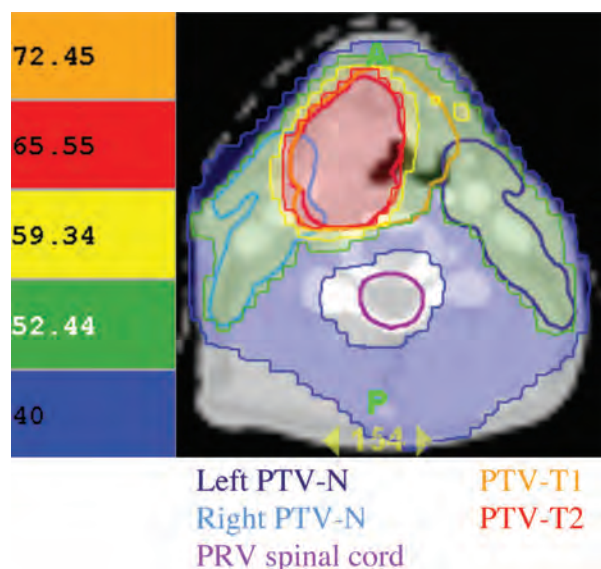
Color wash of the absorbed-dose distributions (in Gy) for the various PTVs. An absorbed dose of 55.5 Gy (30×1.85 Gy, in 6 weeks) was prescribed to the PTV-T1 (FDG-PET, 0 Gy) and the PTV-N (CT, 0 Gy), whereas an absorbed dose of 69 Gy (30×2.3 Gy, in 6 weeks) was prescribed to the PTV-T2 (FDG-PET, 0 Gy). The 72.4 Gy and 65.6 Gy isodoses correspond to 107 % and the 95 % of prescribed absorbed dose to the PTV-T2, respectively; the 59.3 Gy and 52.4 Gy isodoses correspond to 107 % and the 95 % of prescribed absorbed dose to PTV-T1 and PTV-N, respectively.
